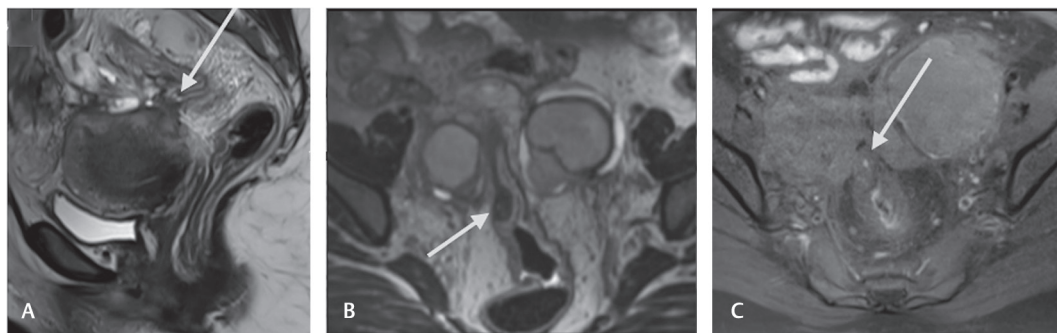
(A–C) T2W sag (A) image showing a deep deposit on the serosal surface of the uterus extending into the wall of the rectosigmoid (*arrow*). Oblique T2W axial image showing an endometriotic deposit in the wall of the rectosigmoid with intact mucosa—mushroom sign (*arrow*). T1W FS axial image (*arrow* in C) showing foci of hyperintensity consistent with endometriosis. T1W, T1-weighted; T2W, T2-weighted.
